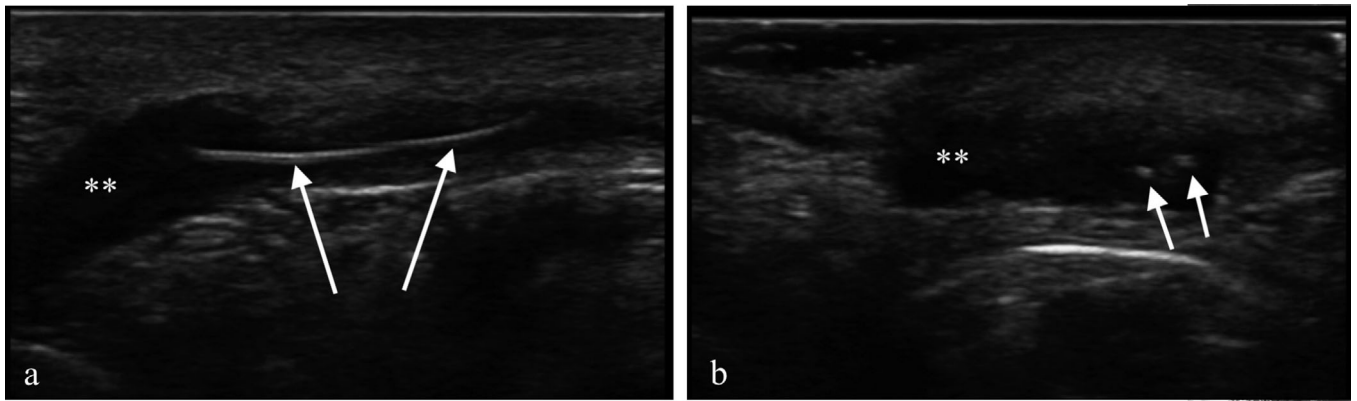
Ultrasound image of nodule. Left side (A) demonstrating hyperechoic structures (long white arrows) appearing linear in long axis within a hypoechoic fluid collection (twin asterisks); right side (B) showing hyperechoic structures (short white arrows) that appear as twin dots in short axis within hypoechoic fluid collection (twin asterisks)
